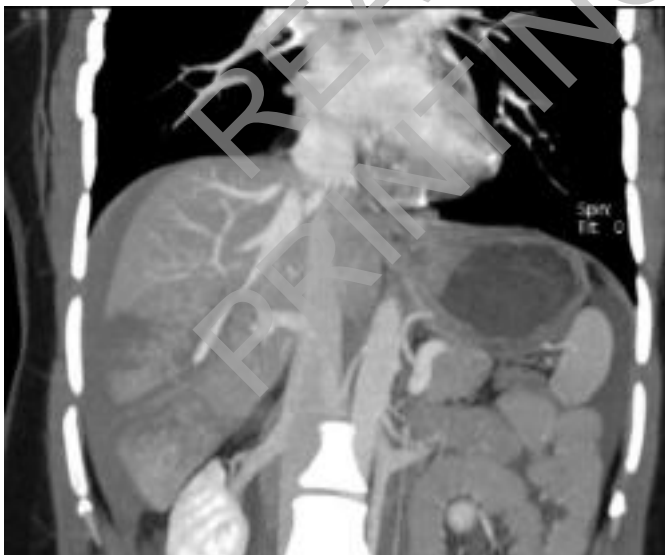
CT scan (coronal view) – Some peripheral ramifications of the right branch of the portal vein are unrecognizable; in addition, one of the branches of the right suprahepatic vein appears reduced at its middle third and only distally returns to its regular caliber.
